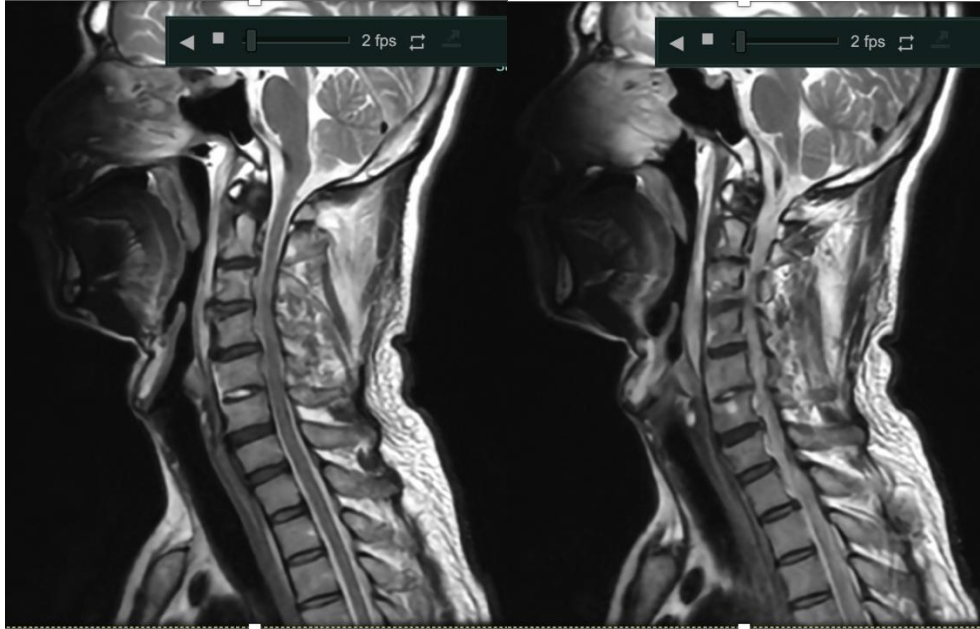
Sagittal T2-weighted MRI of the cervical spine without contrast (August 1, 2025), demonstrating bone marrow edema at C3–C4, spinal cord edema at C2–C3, disc herniation at C3–C4, and degenerative changes with syndesmophytes at C5–C6 accompanied by intradiscal fluid collection. Additional findings include disc herniation at C4–C5 and C7–T1 causing mild central canal stenosis, as well as hypertrophy of the ligamentum flavum and bilateral facet joints at C7–T1 resulting in mild bilateral lateral recess and foraminal stenosis.
